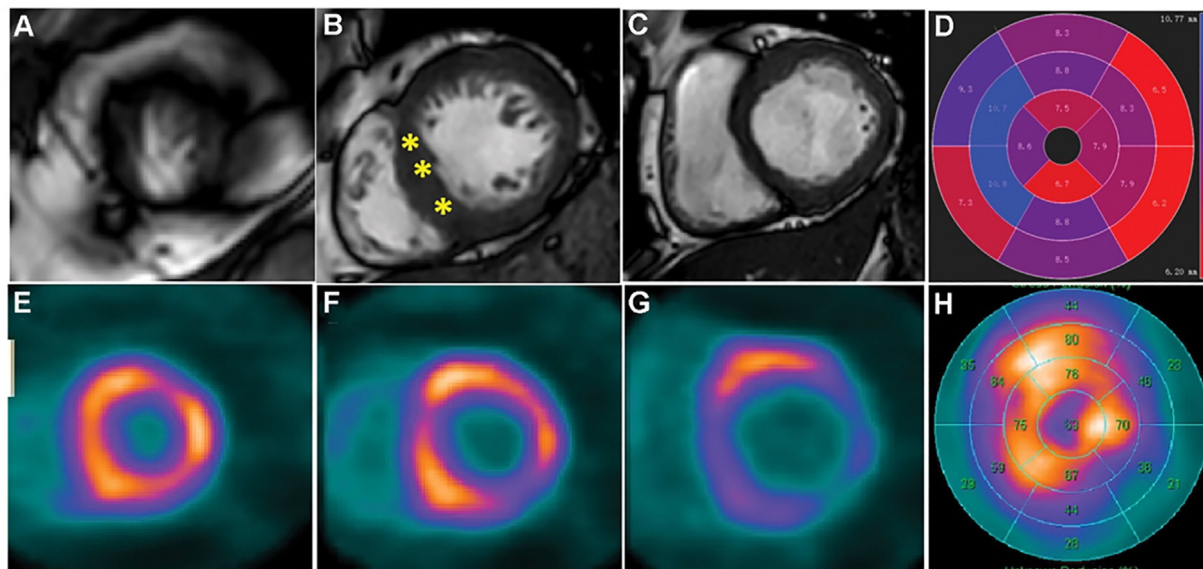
Example of ^{68}Ga -FAPI uptake in hypertrophic cardiomyopathy. (A–D): Image of a patient with HCM demonstrating that involved myocardium extended beyond areas of hypertrophy. The selected short-axis images from cardiac MRI (A–C) showed hypertrophic midseptum (15 mm, *), which is presented with a polar plot (D). E–H: Corresponding short-axis images of ^{18}F -FAPI (E–G) and polar plot (H) indicated the larger area of cardiac fibroblast activation beyond the hypertrophic region. This research was originally published in *Radiology*. Wang et al. Myocardial Activity at ^{18}F -FAPI PET/CT and Risk for Sudden Cardiac Death in Hypertrophic Cardiomyopathy. *Radiology*. 2022. 11; 306(2):e221052. © RSNA. FAPI, fibroblast activation protein inhibitors; HCM: Hypertrophic cardiomyopathy.
